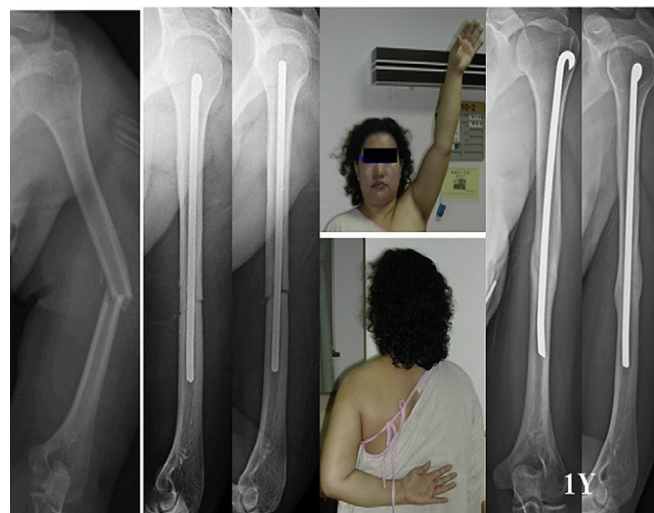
Radiographs of a 42-year-old, 154-cm-tall woman who suffered an isolated AO type A3 humeral shaft fracture secondary to a motor vehicle accident. Operation was done by closed reduction and intramedullary fixation using one 18-cm Rush pin. Although the pin was shorter than the desired length, it still “filled up” the medullary canal to achieve a stable fixation. Removal of implants was performed 1 year later because of union of fracture, and her upper arm function was excellent.
